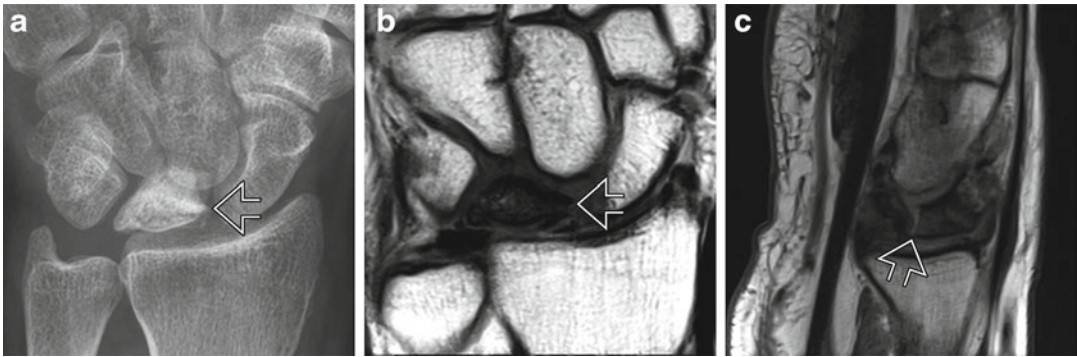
Stage III Kienböck's disease. (a) Radiograph shows lunate sclerosis and collapse (*arrow*). (b) Coronal T1-weighted MR image shows decreased signal intensity, flattening, and loss of height of the lunate (*arrow*). (c)
